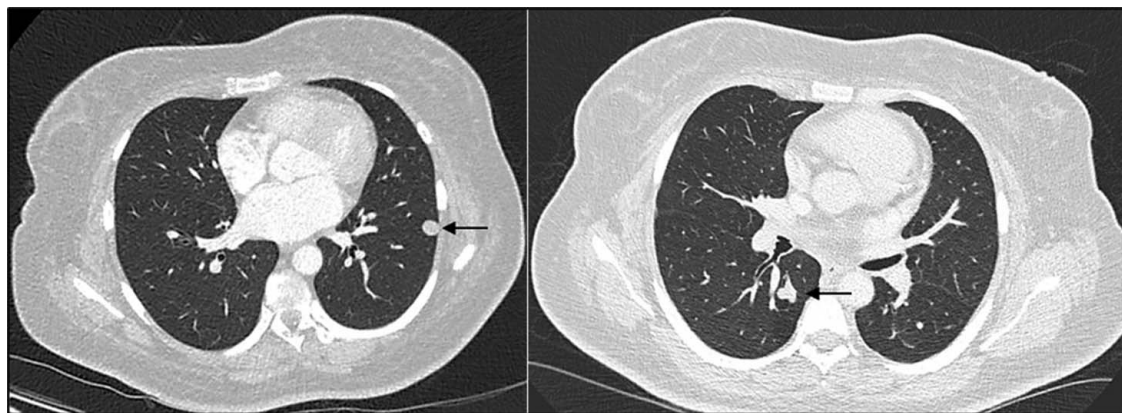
CT Thorax images showing a 12 mm peripheral nodule in the left lower lung (left image) and a bilobed 9 mm nodule in the right middle lung lobe (right image). CT, computed tomography.
